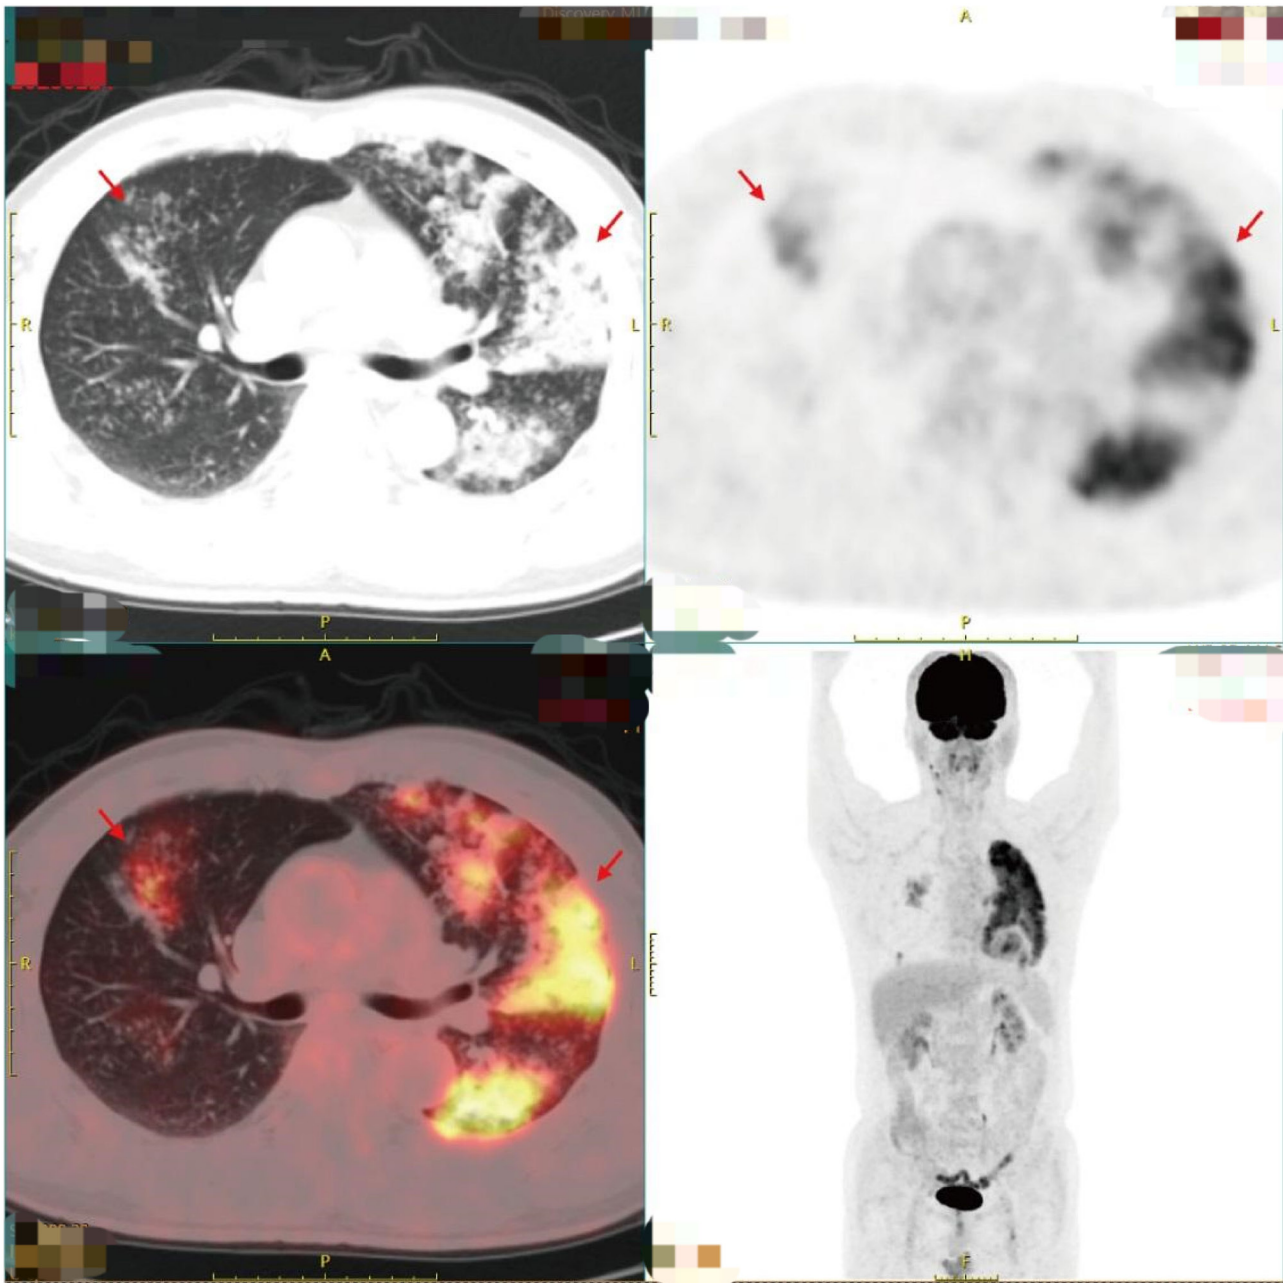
PET/CT revealing diffuse multiple patchy consolidations and nodular shadows in both lungs, mainly in the left upper lung, with increased metabolic activity suggestive of inflammatory lung cancer. The arrows on the left side in each image indicate the multiple patchy, dendritic and small, nodular, high-density shadows that were present in both lungs, particularly in the left lung, which exhibited pulmonary consolidation. The arrows on the right side in each image indicate a solid lung lesion.
